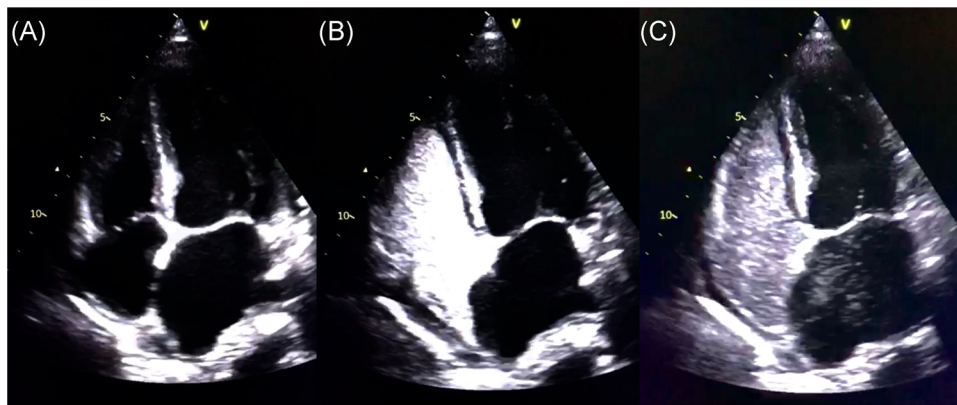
Intrapulmonary vascular dilatation (IPVD) grade IV diagnosis by contrast-enhanced transthoracic echocardiography. A, transthoracic echocardiography before contrast injection; B, microbubbles contrasting the right side of heart immediately after contrast injection; C, large number of bubbles in left atrium modifying echogenicity, after three heartbeats, determining a grade IV IPVD
